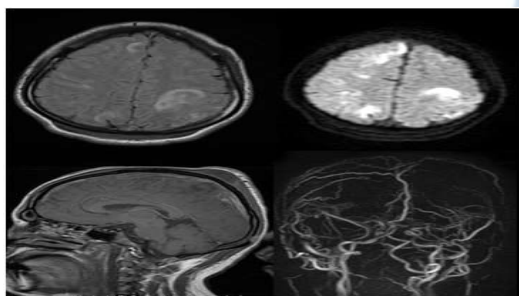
23 y old woman with 5 months of amenorrhea day, c/o headache, Axial T2 FLAIR, DWI, Sag T1 and MRV reveals venous infarct in bilateral frontal lobe secondary to thrombosis of superior sagittal and bilateral transverse sinuses.
